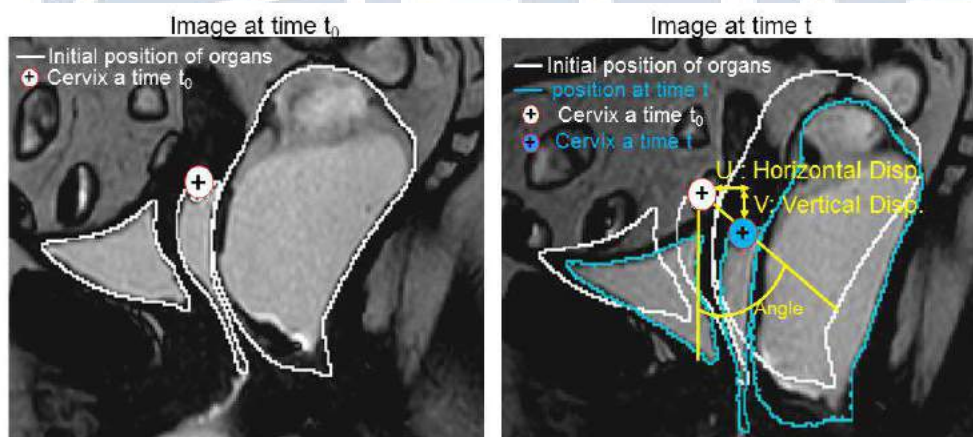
Assessing pelvic mobility using MRI.
